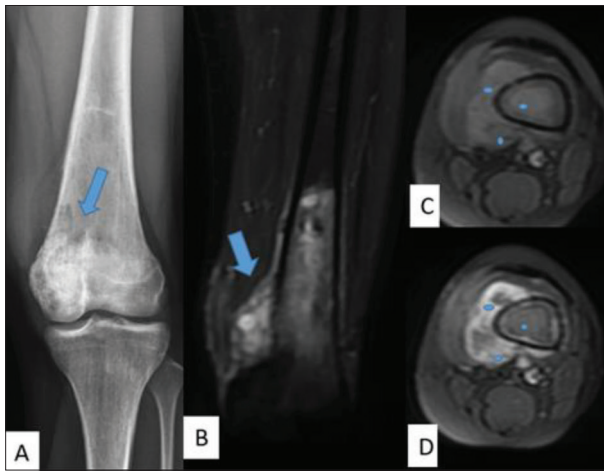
Osteoblastic osteosarcoma: A – anteroposterior radiograph shows a lytic sclerotic lesion of the distal femoral epiphysis-metaphysis (arrow); B – coronal T2 fast spin echo magnetic resonance image, distal femoral intramedullary tumor, and extraosseous extension (arrow); C – axial T1 fast spin echo magnetic resonance image; three dots indicate region of interest measurement sites; D – axial postcontrast T1 magnetic resonance image three region of interest marks placed in the same location
